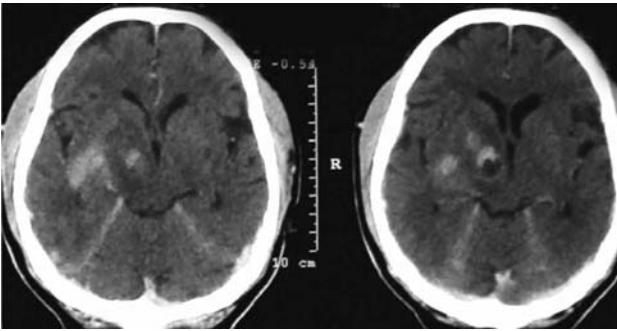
Axial brain CT scan showing multiple enhancing brain lesions.
